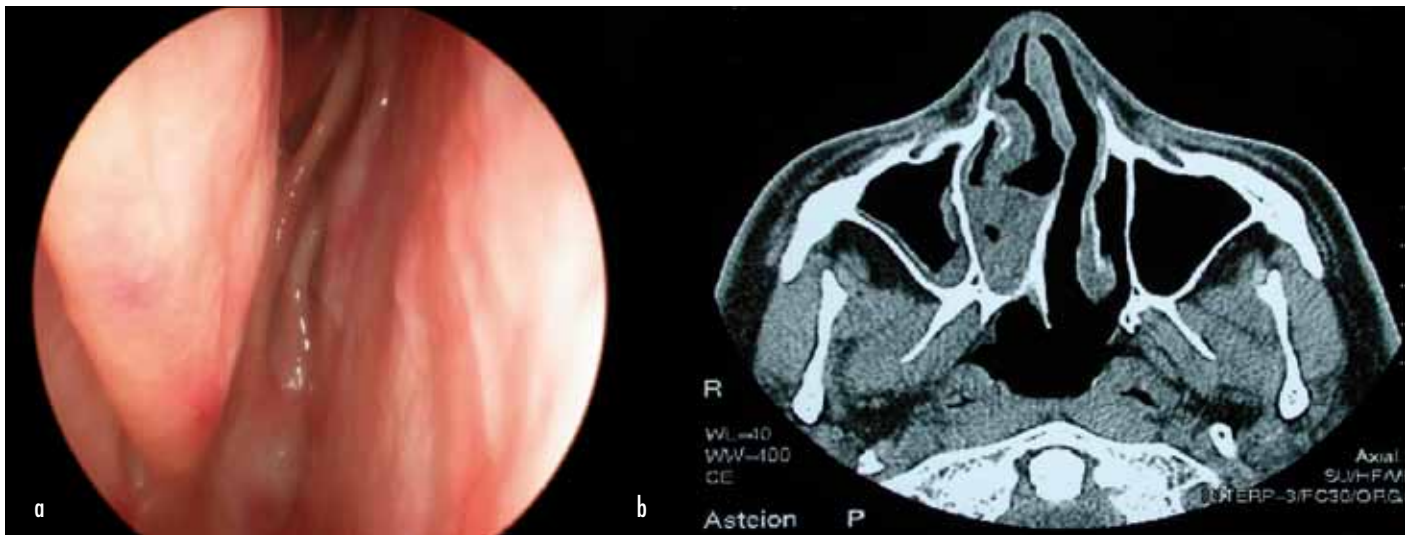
a. Endoscopic view of the obstructed nasal cavity as a result of choanal atresia. b. Corresponding axial computed tomography scan of the same patient demonstrating unilateral choanal atresia.
